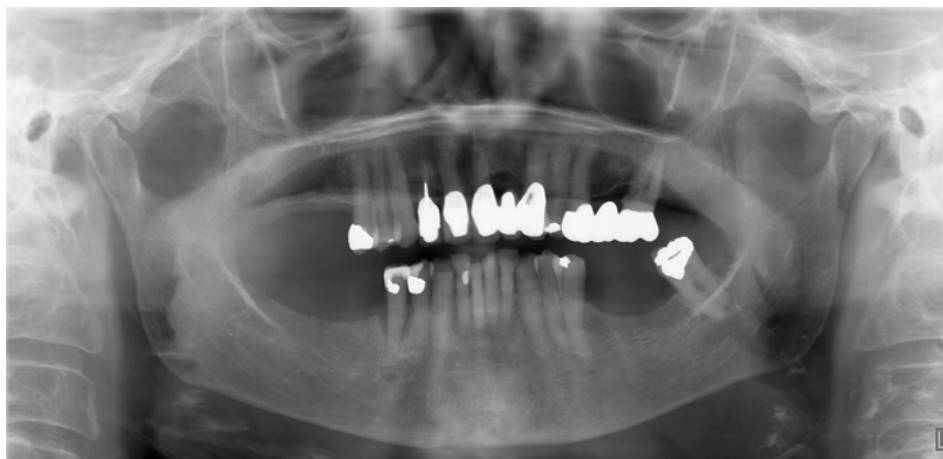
This panoramic radiograph shows the C2 Late stage of osteoporosis, showing semilunar defects extending more than half the cortical width of the inferior mandibular cortex with a very thin cortex by visual estimation.
